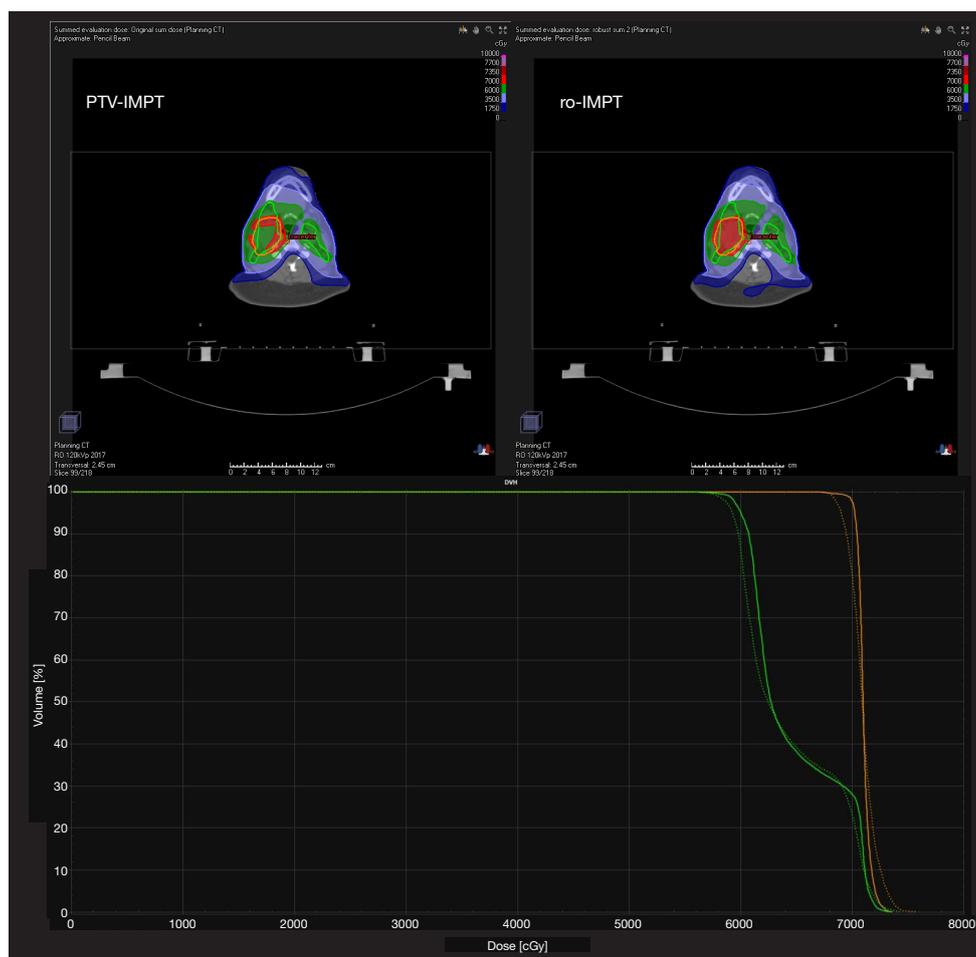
A representative case of sCT and vCT comparisons in proton dose distribution. The 3D gamma index dose comparison (3 mm/3%) showed an average pass rate of $98.2\% \pm 1.5\%$ comparing the same day's pair of sCT and vCT. PTV, planning target volume; IMPT, intensity modulated proton therapy; ro-IMPT, robust optimized IMPT; sCT, synthetic-CT; vCT, verification-CT; DVH, dose-volume histogram.
